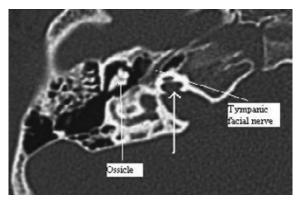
I Axial CT image of the right petrous temporal bone.
